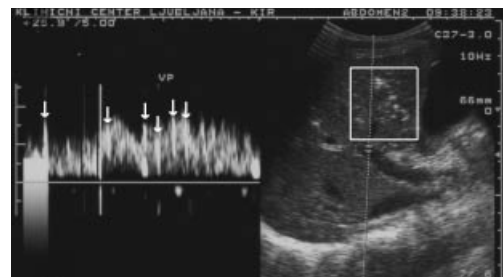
Doppler sonogram of a portal vein showing multiple high-amplitude spikes (arrows), typical of intravascular gas.
